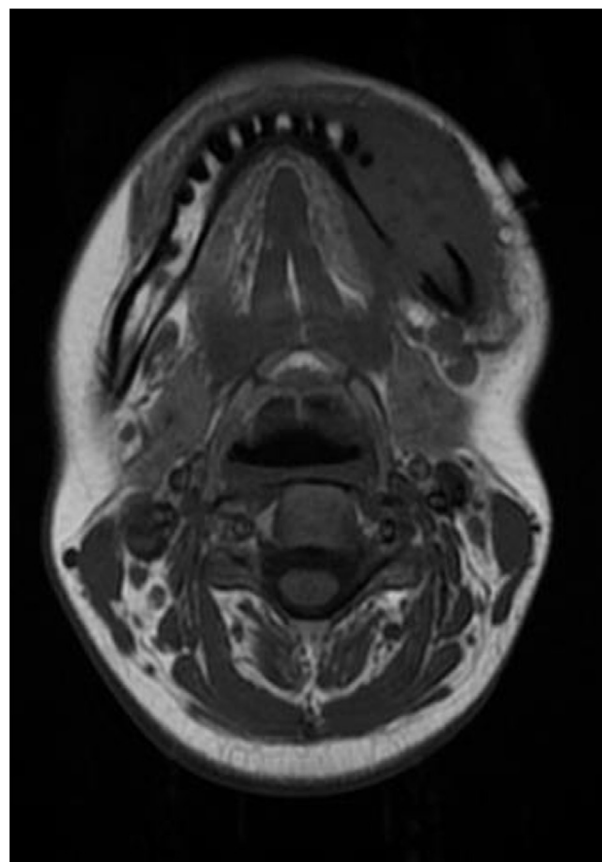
Axial MRI (T1 weighted).
